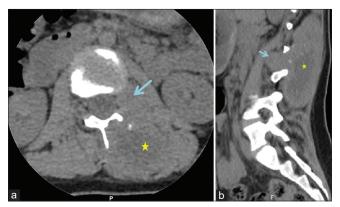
Selected computed tomography images of the spine. Axial (a) and sagittal (b) views demonstrate the left paraspinal soft-tissue mass (*) with an area of calcification that is extended from the level of T12/L1 down to the L4 level vertebra. Note the bone erosion changes in the lamina at the axial plane and the extension into the L1/L2 left neural foramina (arrows).
